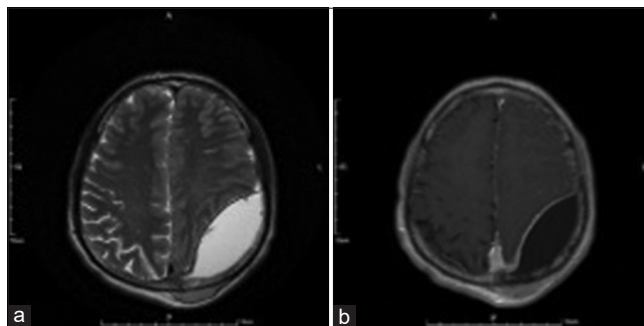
Brain magnetic resonance imaging. (a) An axial T2-weighted image revealing a soft-tissue lesion of the left parietal scalp and epidural fluid collection in the left parietal region with mass effect. (b) An axial T1-weighted image with gadolinium contrast showing mild enhancement of the soft tissue on the scalp and diffuse dura
